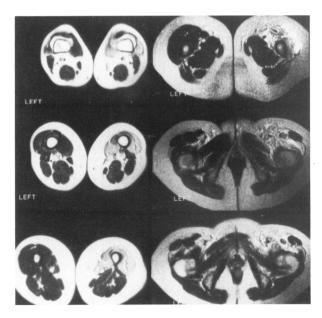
Six different levels through the thigh demonstrate an abnormality of the vastus muscles, the rectus femoris, and the pectineus muscle. The tensor fascia lata is spared. This pattern of muscular abnormalities reflects the distribution of the femoral nerve. The patient was ultimately demonstrated to have a lymphoma of the pelvis which caused the neuropathy. Interestingly, the lymphoma was demonstrated by CT, but not by MRI>
